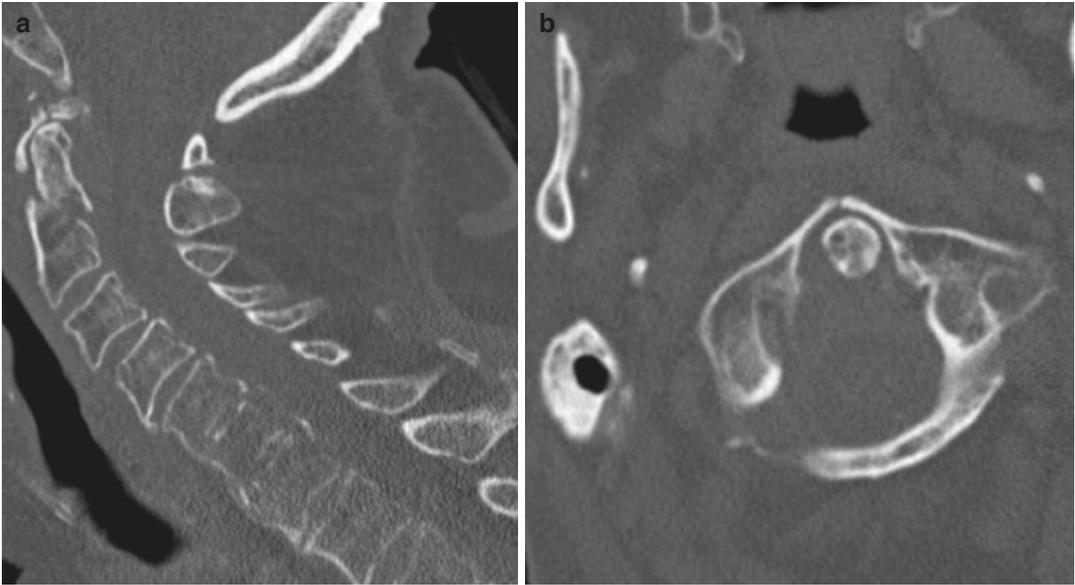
Initial CT Scan. Sagittal (a) and axial (b) CT scan rendering type II odontoid fracture
